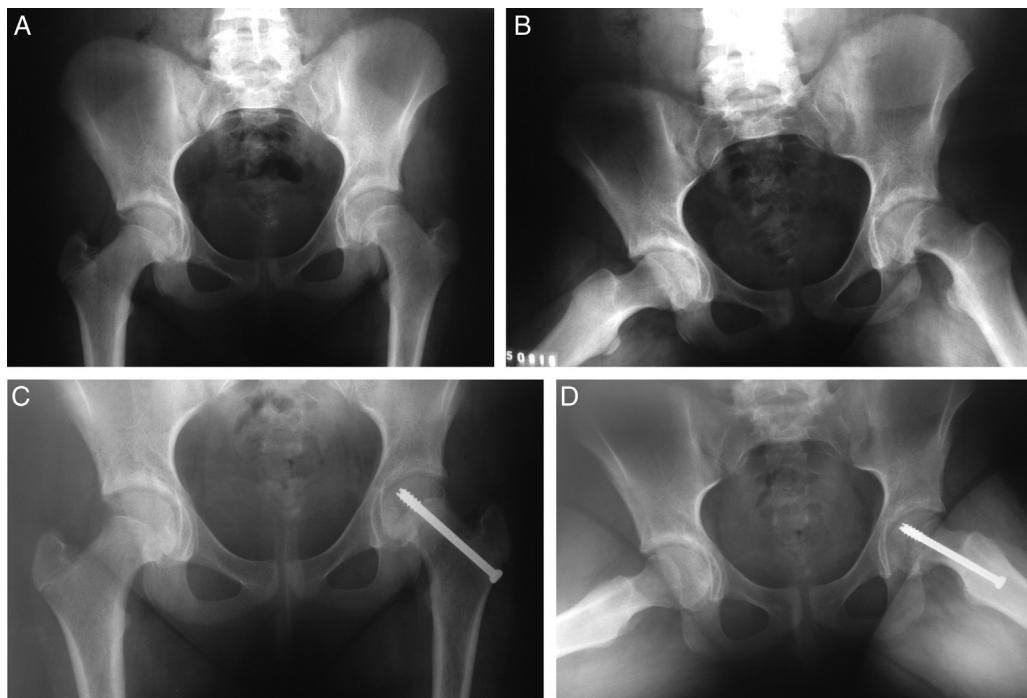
Female patient aged 12 years and two months. Pain in the left hip for one month, was able to walk without crutches. Hip locked in IR, 90° of flexion. (A) and (B) Preoperative radiographs showing Southwick grade II SCFE to the left, EDA 45°. (C) and (D) Postoperative radiographs at six months of follow-up disclosing deformity correction, EDA 6°.
